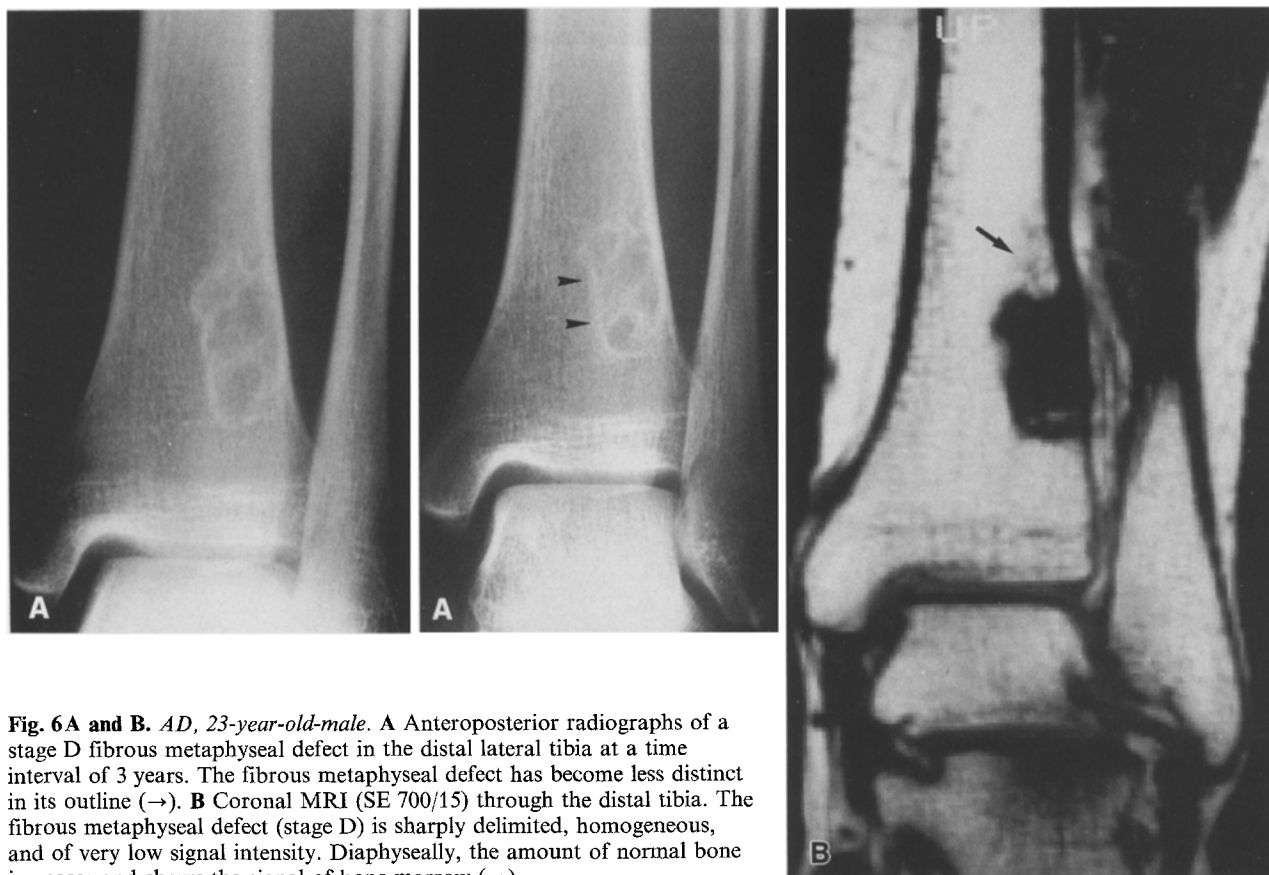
A and B. AD, 23-year-old-male. A Anteroposterior radiographs of a stage D fibrous metaphyseal defect in the distal lateral tibia at a time interval of 3 years. The fibrous metaphyseal defect has become less distinct in its outline (→). B Coronal MRI (SE 700/15) through the distal tibia. The fibrous metaphyseal defect (stage D) is sharply delimited, homogeneous, and of very low signal intensity. Diaphyseally, the amount of normal bone increases and shows the signal of bone marrow (→)
